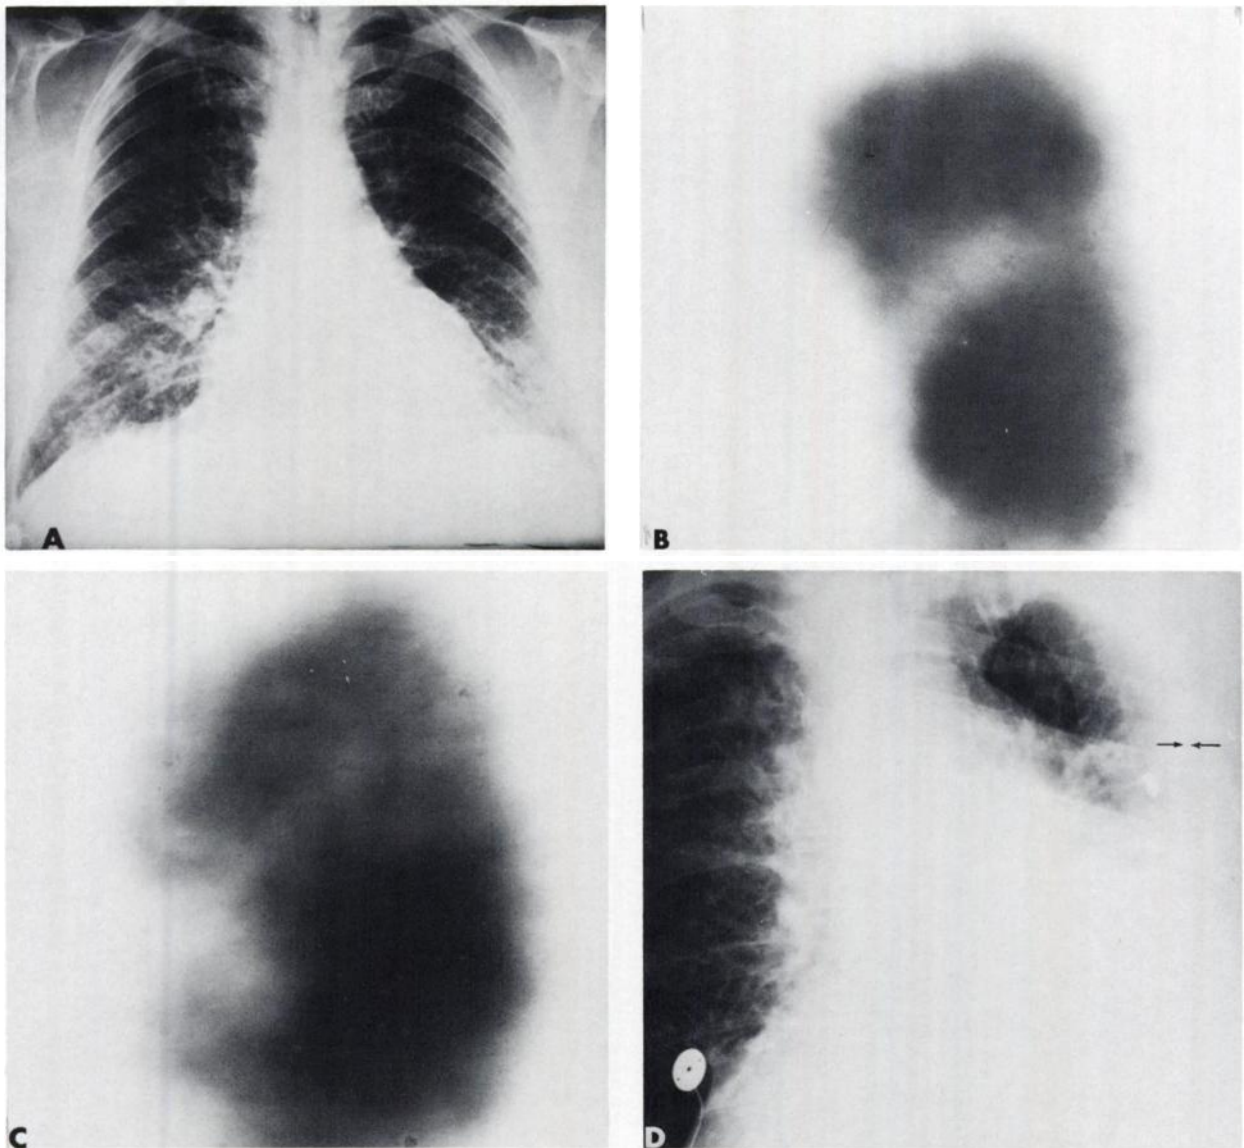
Pleural fluid. 64-year-old man with history of recurrent myocardial infarct and congestive heart failure. Initial upright PA chest roentgenogram, A, showed no fluid. Left lateral scan performed with left side down and gamma camera head beneath
